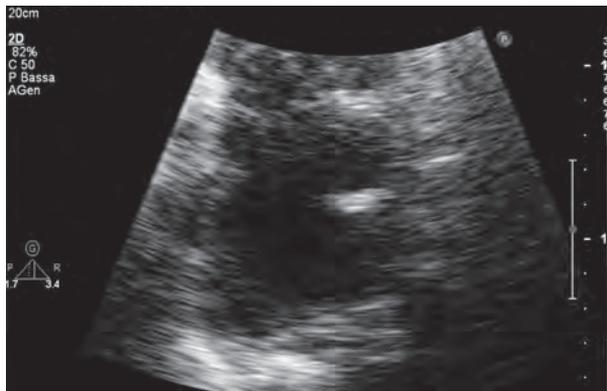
Transthoracic two-dimensional echocardiography showing a hyperechogenic mass, in the four-chamber apical view, apparently attached to the left atrial lateral wall and protruding in the atrial lumen
